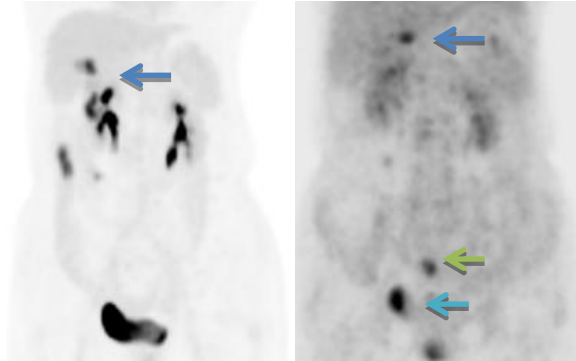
⁶⁸Ga-citrate detected ileac DLBCL lesion, but ¹⁸F-FDG did not. Omentum majus (blue arrow), ileum (green arrow), ileocecal junction (brilliant blue arrow)
